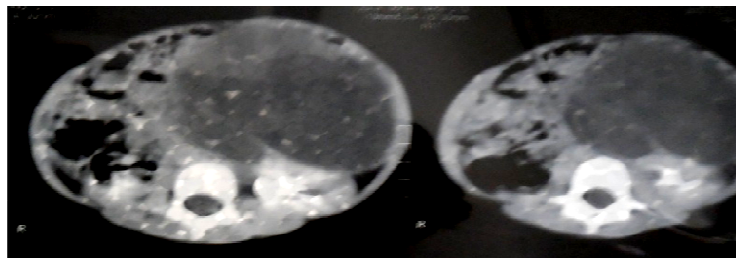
CT image of the retroperitoneal cystic mass
